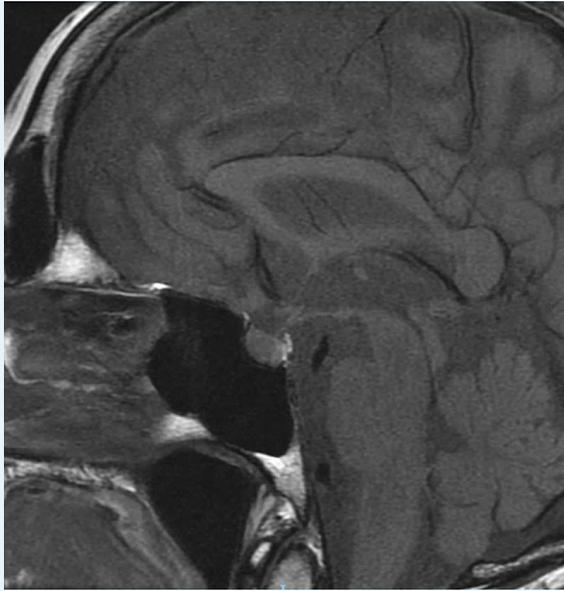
Absence of the normal hyperintense signal of the posterior hypophysis on MRI
